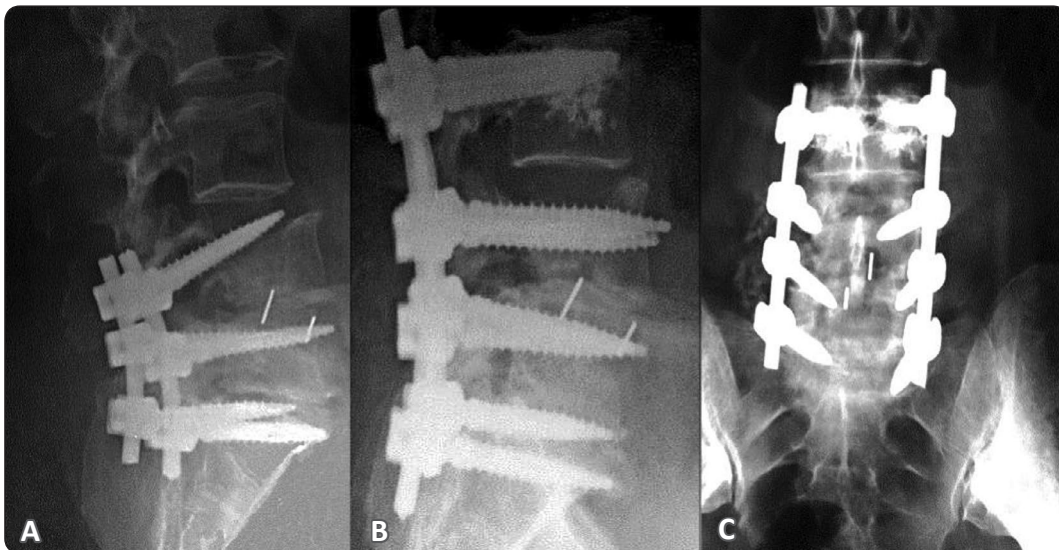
Interbody cage subsidence in 65 years old male. (A) lateral X-ray film revealed cage with grade II subsidence together with a loosening of the L4 screws. (B) L3/S1 lateral X-ray showed sagittal reconstruction with bi-cortical screw insertion at L4 and cement augmented screw at L3 screw. (C) Ant-Post X-ray show construct and the intertransverse posterolateral iliac crest bone graft.
